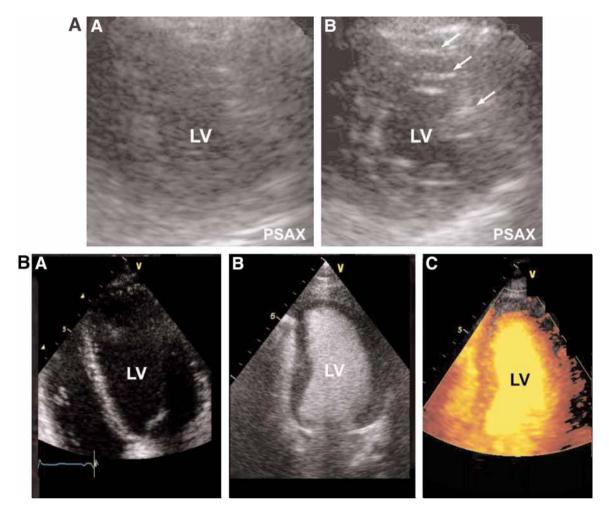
(A) Tissue harmonic imaging. Even with suboptimal imaging (left panel, parasternal short axis view of the left ventricle) tissue harmonic imaging markedly improves endocardial definition. Note reverberation artefacts (arrows) arising from ribs. (B) Left ventricular opacification/endocardial border definition. Contrasts methods assist in delineating the endocardial border. Left ventricular opacification using microspheres (e.g., Optison® or Definity®) are popular (compare left and middle panels). Another myocardial contrast imaging technique is shown in right panel. (Please *see* companion DVD for corresponding video.)
